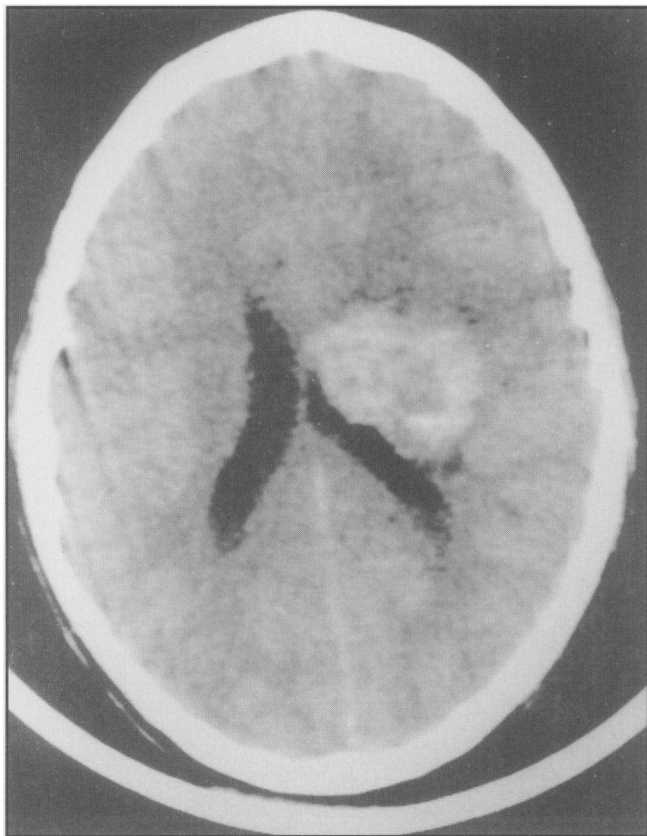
Axial CT scan (unenhanced).
